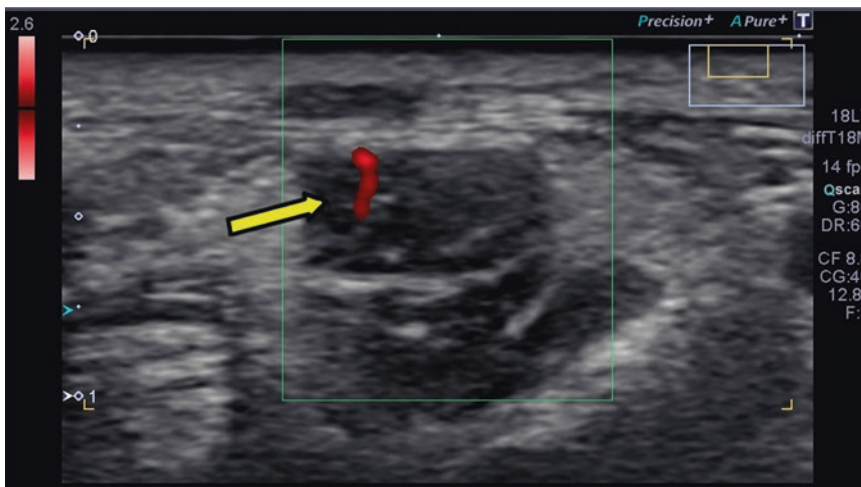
Axial ultrasound image—median nerve enlargement with intraneural vascularity by color Doppler (*arrow*). Image provided courtesy of Toshiba America Medical Systems, Inc.
